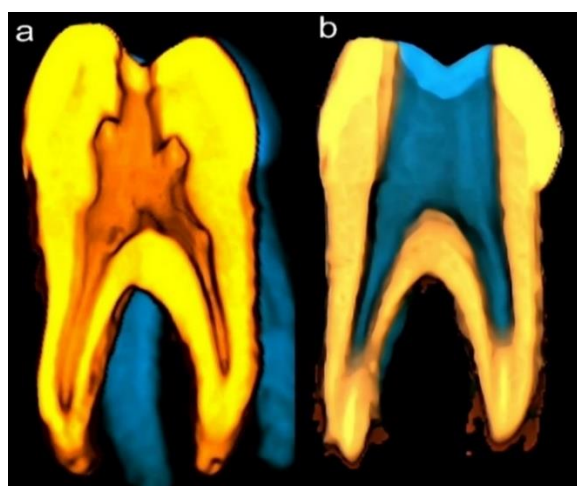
Cone beam computed tomography image (sagittal view) shows (a) conservative endodontic access cavity and (b) traditional endodontic access cavity
